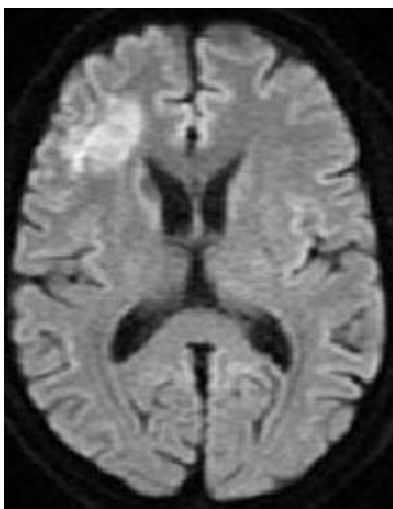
MRI brain showing hyperintense lesion in the right frontal area
